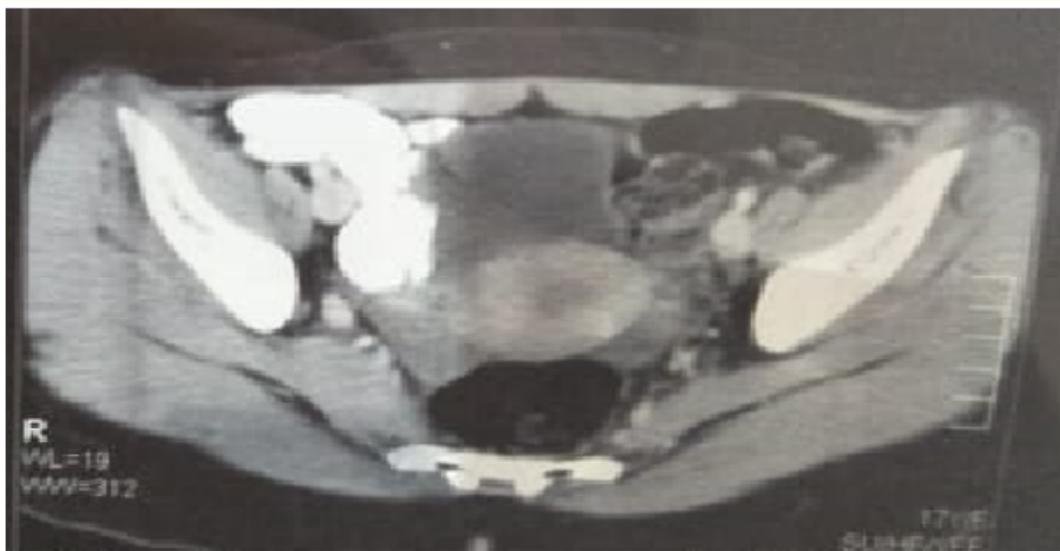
Computed tomography coronal view showed left ureterocele impression inside urinary bladder.
